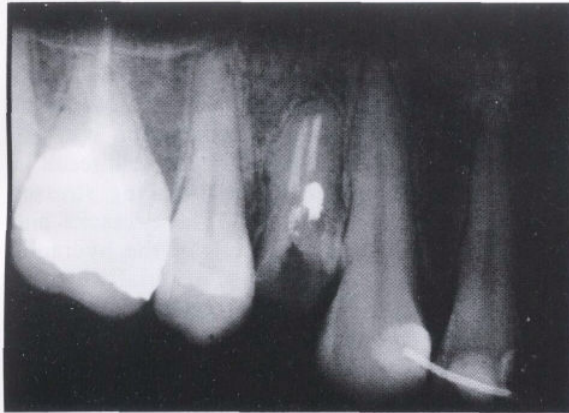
Radiograph of first premolar after removal of amalgam restoration and part of the post in the palatal canal.
